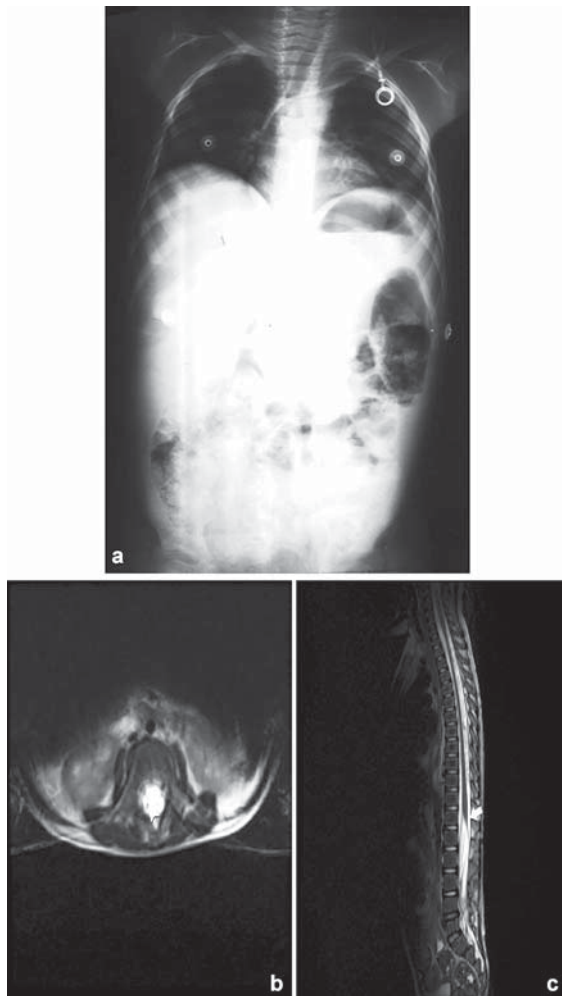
Bilateral diaphragmatic elevation and dilatation of the intestinal segments, mainly in the large intestine, on direct abdominal X-ray. 1b. Milimetric nodular defective appearance (arrow) at the conus medullaris level T11- T12 on T2-weighted axial MRI. 1c. Thickening of the conus medullaris and cauda equina seen on T2-weighted sagittal MRI.
